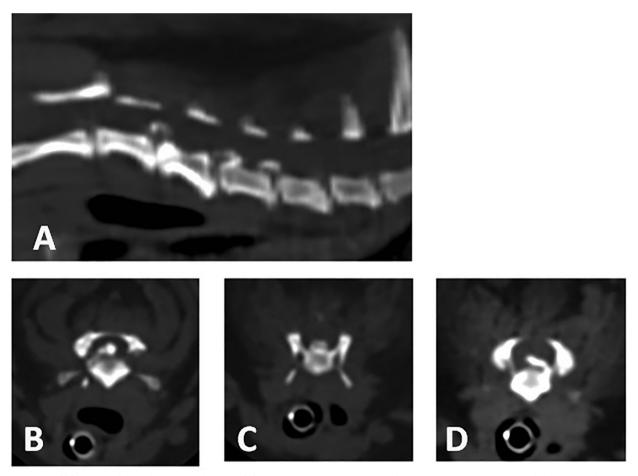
CT images of the affected spinal region. (A) Reconstructed sagittal view of the neck showing mineralized disc material in the vertebral canal at intervertebral spaces C3-C4, C4-C5 and C5-C6. (B-D) Transverse slices show mineralized disc in the spinal canal at intervertebral disk spaces C3-C4, C4-C5 and C5-C6, respectively, causing spinal cord compression.
